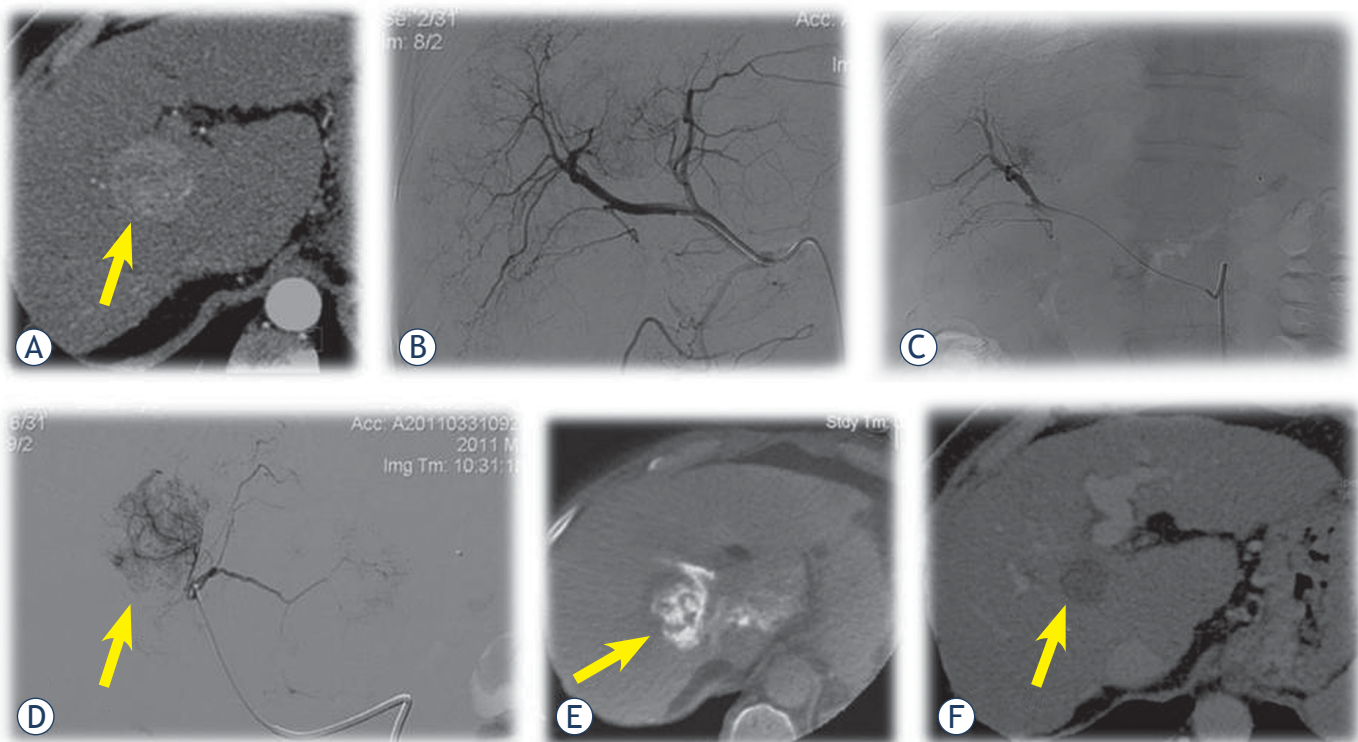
A 56-year-old female with HCC. (A) Contrast-enhanced CT shows tumor (arrow) between right and left liver lobe. (B) Initial angiography shows tumor in the liver (arrow). (C) Superselective contrast injection through microcatheter into segmental branches for eight liver segment confirms the tumor. (D) Superselective contrast injection through microcatheter into segmental branches for first liver segment also confirms the tumor (arrow). (E) CBCT after contrast injection through microcatheter into segmental branches for first liver segment confirms that the target lesion (arrow) is dominantly supplied from this artery and superselective DEBDOX TACE was performed from both artery. (F) Two months after the DEBDOX TACE, control CT shows complete devascularization of the target lesion (arrow) (complete response).
